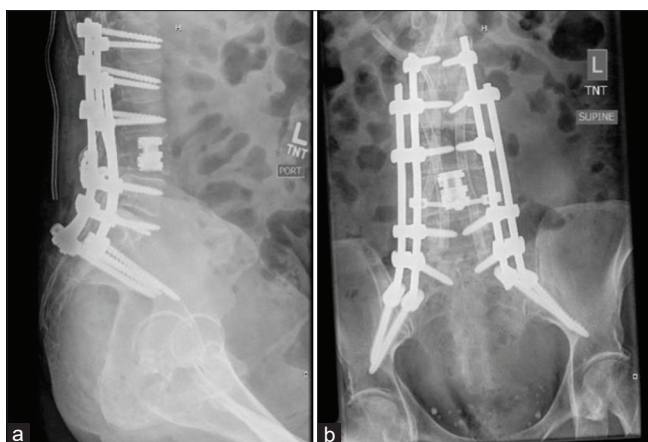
Lateral (a) and anterosuperior (b) X-rays of the lumbar spine demonstrating placement of a L4 corpectomy with placement of a cage and quad rod, pedicle screw instrumentation at L1, L2 and L3, L5, S1, and across the sacroiliac joints with an interlock at the L4 level.
